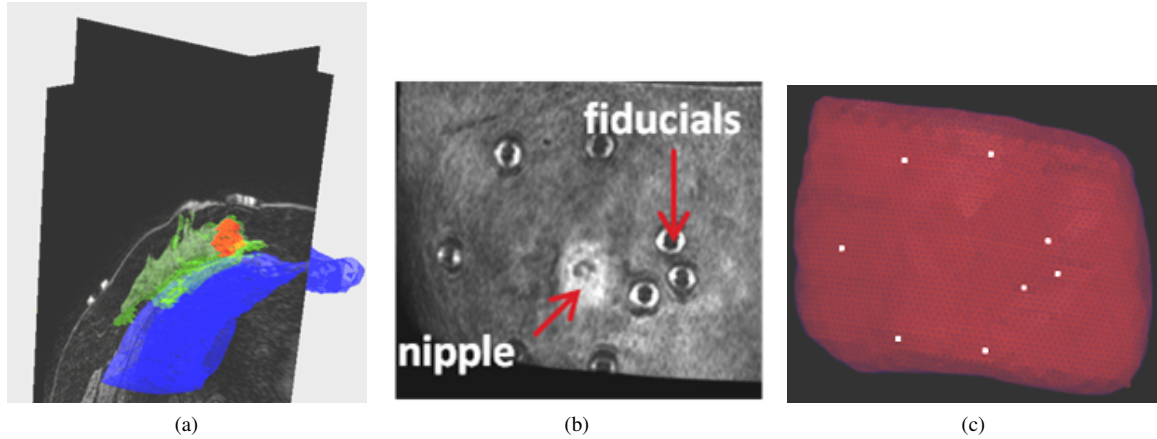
4: Segmentation of preoperative supine MR images: (a) segmentation of glandular tissue in green, chest wall in blue, and tumor in red. (b) is a volume render of the supine MR image, (c) preoperative mesh showing location of fiducial centers in white.
